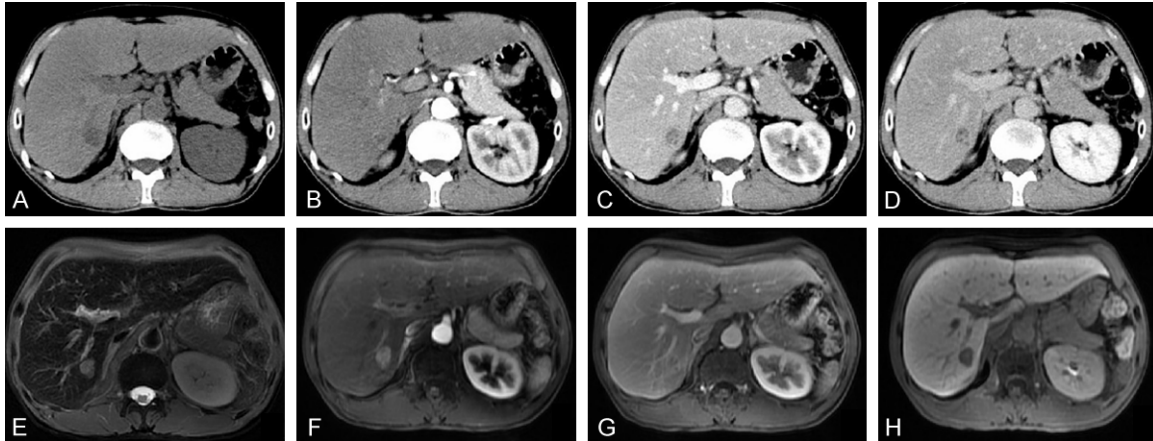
Analysis of a typical case. A: A type of circular low density was noted in the inferior segment of the right posterior lobe of the liver; B: The edge of the lesion was strengthened, the contrast agent gradually increased; C: The contrast agent in the lesion in the portal venous phase gradually increased; D: The contrast agent in the lesion at the equilibrium stage gradually increased; E: The nodules on the T2-weighted image (T2WI) showed hyperintensities compared with the liver parenchyma; F: The nodules in the inferior segment of the right posterior lobe of the liver in the enhancement arterial phase were significantly strengthened; G: The enhancement degree of the nodule in the portal venous phase decreased and showed hypo intensity; H: The nodules in the hepatobiliary specific phase showed no uptake of the contrast agent and hypo intensity.
